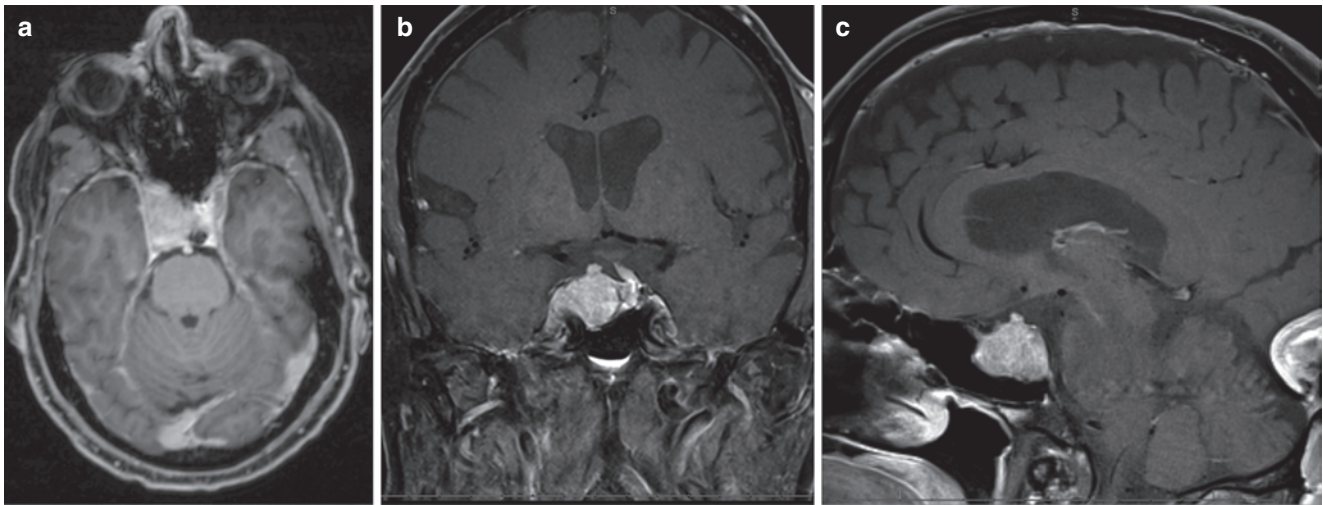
A fine slice T1 MRI with fat suppression showing the pituitary adenoma within the right sella that extended into the right sphenoid sinuses and posterior clinoid process and displaced the pituitary stalk
